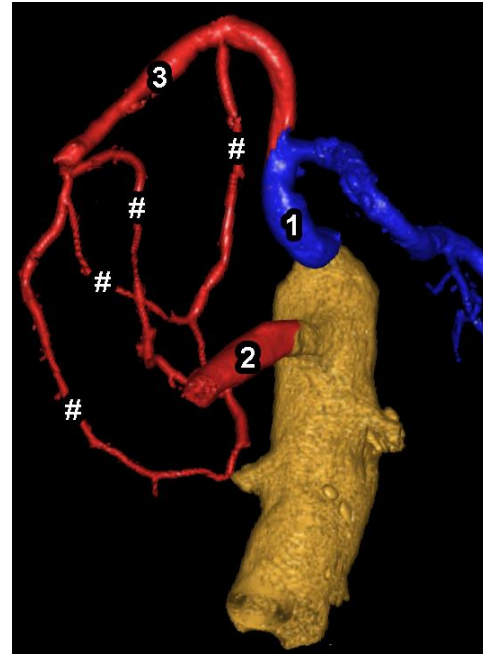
Four pancreaticoduodenal arches. 3D CT reconstruction. [28]
